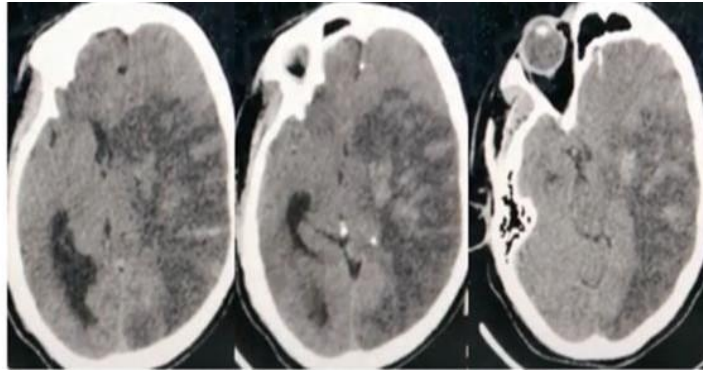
Sub-acute left middle cerebral artery (MCA) is shown on a 45-year-old man's brain non-contrast CT scan.
